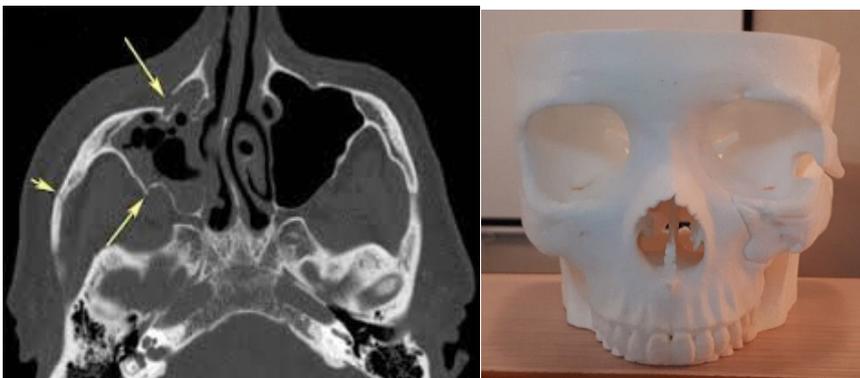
CT scan and 3D model of tripod quadrilateral pod fracture
